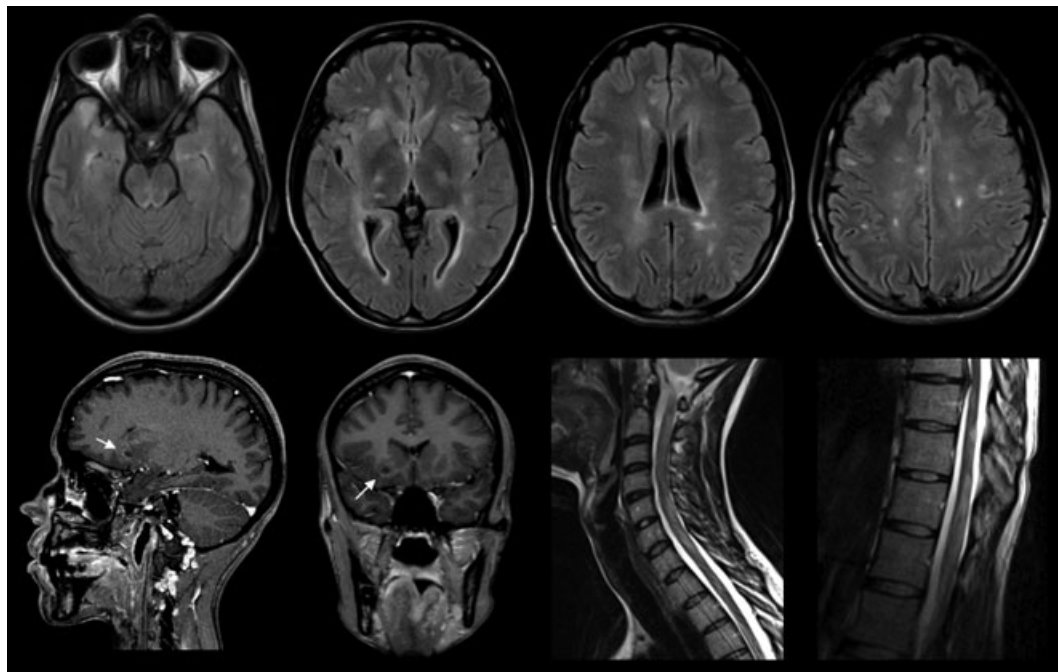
Top: multiple and disseminated white matter lesions on FLAIR-weighted imaging; bottom left: right frontal contrast-enhancing lesion on T1-weighted imaging after administration of gadolinium (arrow); bottom right: cervical (left) and lumbar (right) extensive myelitis on T2-weighted imaging.
